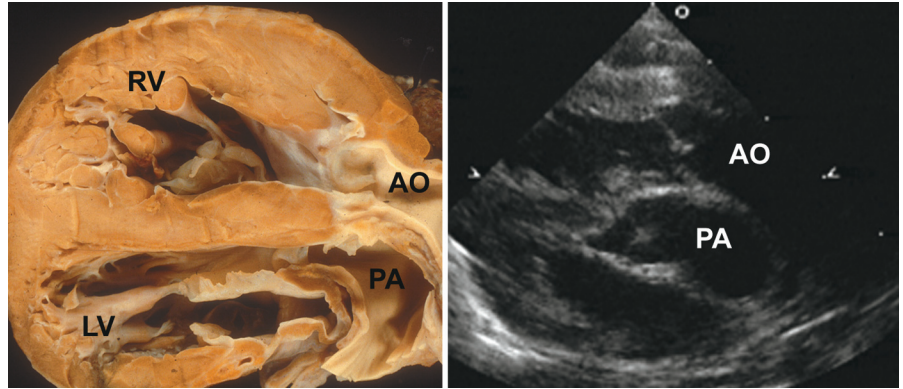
Parasternal long-axis view of TGA. Note the parallel nature of the aorta and pulmonary artery. AO = aorta; LV = left ventricle; PA = pulmonary artery; RV = right ventricle.
